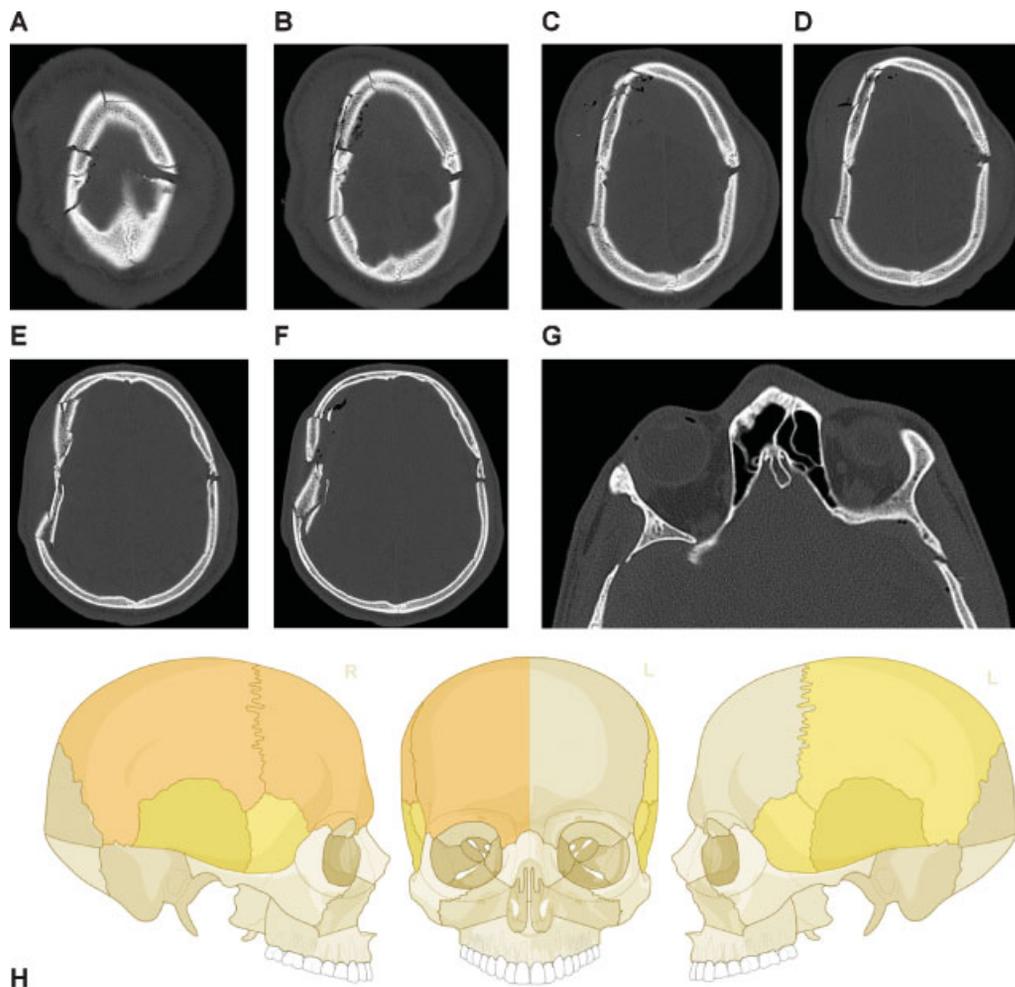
Multiple cranial vault fractures. (A–F) Multiple cranial vault fractures. The right sided fractures involve the frontal and parietal vault with comminution and depression and extension inferiorly into the temporal cranial vault. Similarly, on the left, there is a linear parietal vault fracture that appears to continue into the temporal bone. (G) There is extension of these fractures into the left and right sphenoid bone. Imaging: Computed tomographic axial views. (H) Level 3 code: 93 S0.m.S0, 94 F1.P1.T0.m.T0.P0. This case example CMTR-93-94-001 is made available electronically for viewing using the AOCOIAC software at www.aocmf.org/classification.
